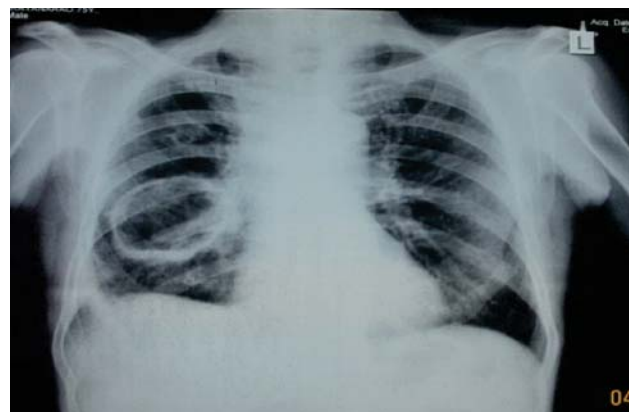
Chest radiograph (postero-anterior view) showing carcinoma lung resembling tuberculosis.
